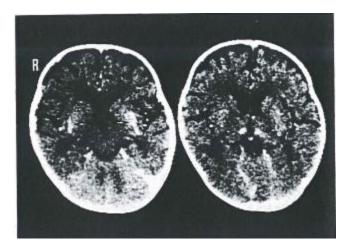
In the enhanced CT scans taken on October 14, there are areas of high density visible in both the thalami (indicated by arrowheads) and the putamen (marked by arrows) on both sides of the brain.
